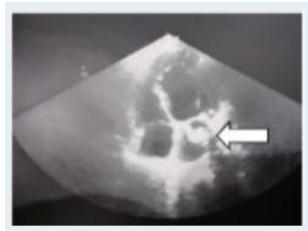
TTE: Apical four-chamber (A4C) view: heterogenous left atrium mass
